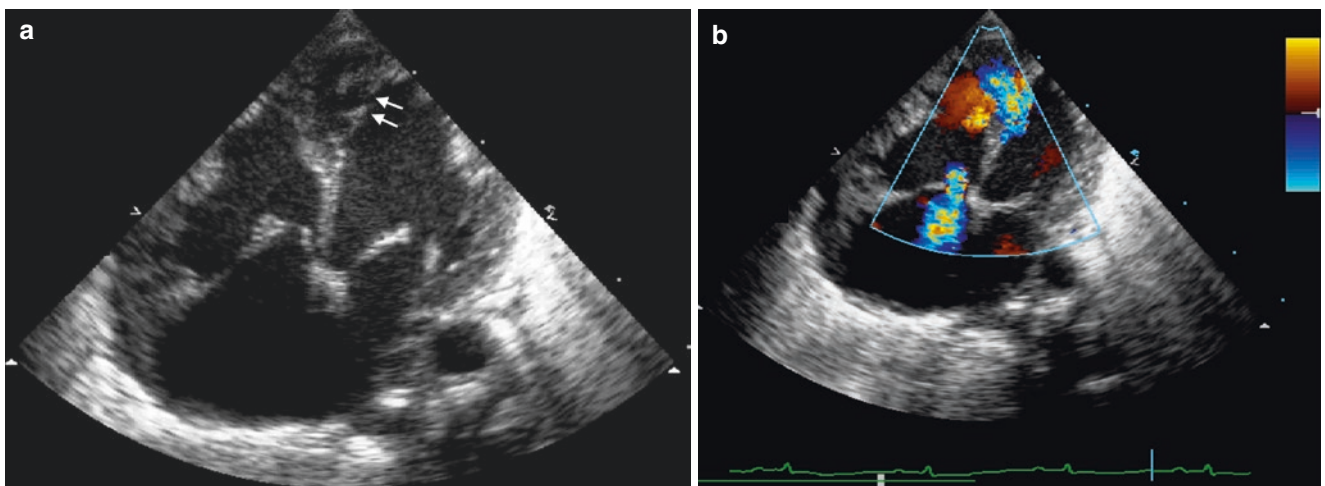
Large apical muscular VSD (*arrows*) in the apical four-chamber view (a). Colour Doppler confirms significant shunting across the defects and shows tricuspid regurgitation (b)
